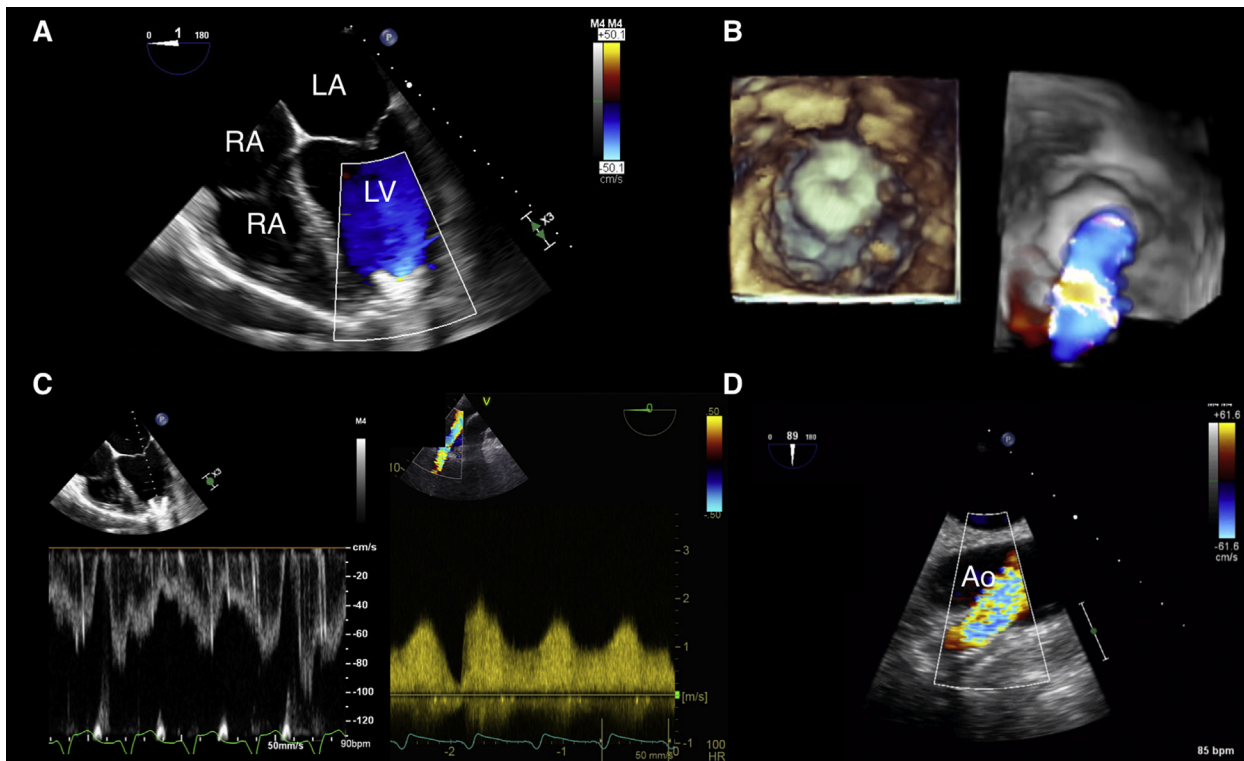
Unobstructed LVAD inflow cannula shown in the ME 4-chamber view (A) and by 3D in en face perspective (B). (C) Doppler interrogation of a HeartMate 3 (Abbott-Thoratec, Chicago, IL) LVAD inflow cannula (left side) and outflow graft (right side). (D) CFD interrogation of an LVAD outflow graft-to-ascending aorta anastomosis. Abbreviations: Ao, Ascending aorta; LA, left atrium; LV, left ventricle; RA, right atrium; RV, right ventricle.
